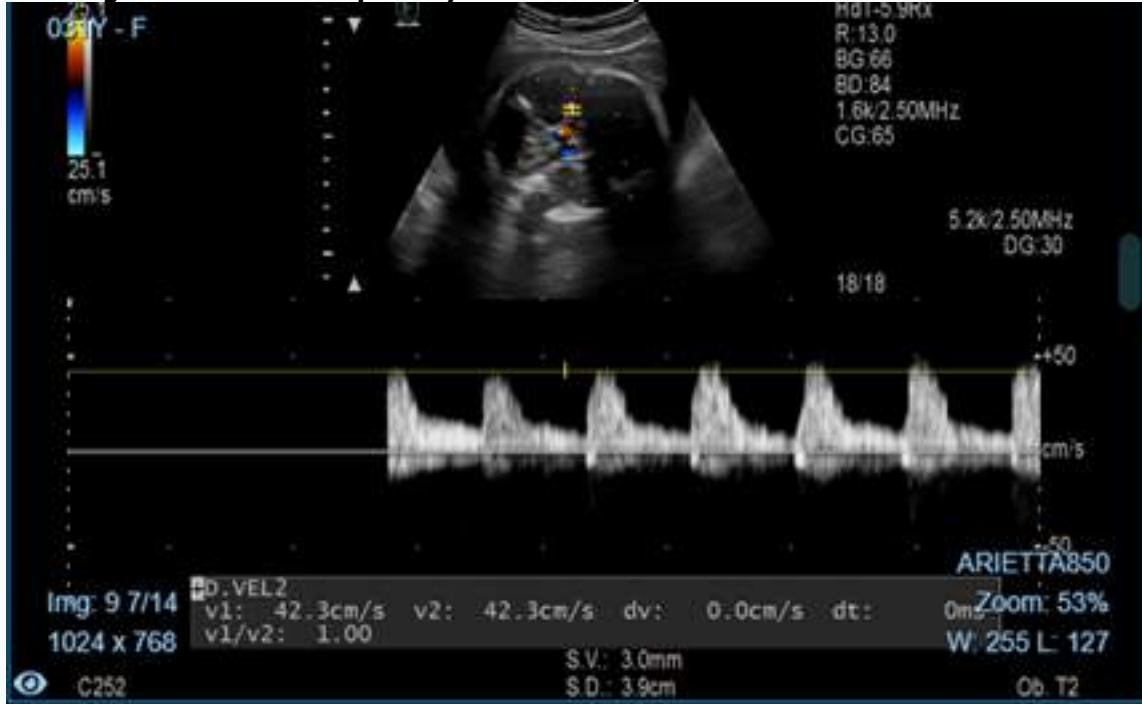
Doppler assessment of the middle cerebral artery (MCA) demonstrating elevated peak systolic velocity (PSV) consistent with fetal anemia.
